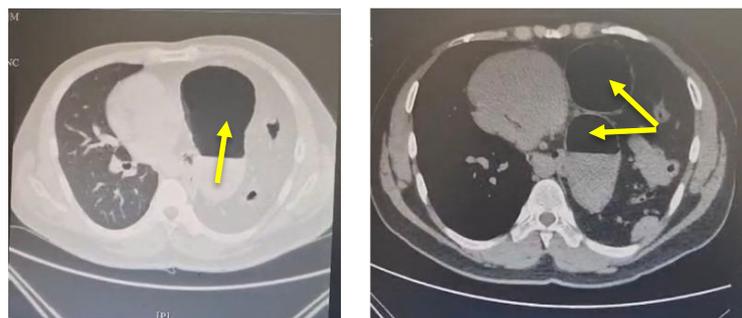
Preoperative axial CT images showed herniation
